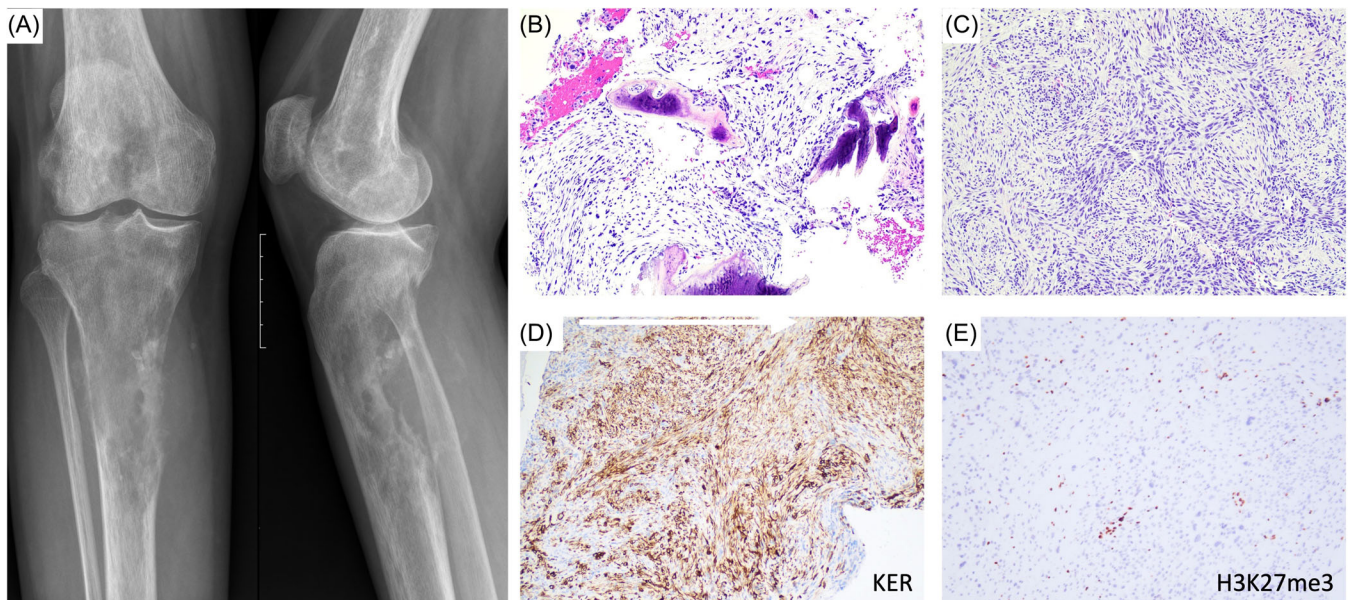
Primary MPNST of bone with *UPF2::NTRK3* fusion, occurring in the proximal tibia of a 29-year-old female. Plain radiograph shows an ill-defined destructive bone tumor with cortical breakthrough and soft tissue extension (A). The tumor is composed of perpendicular fascicles of monomorphic hyperchromatic (blue) spindle cells (B–C), which show expression of cytokeratin (D) and loss of trimethylated histone protein H3K27 (E).
